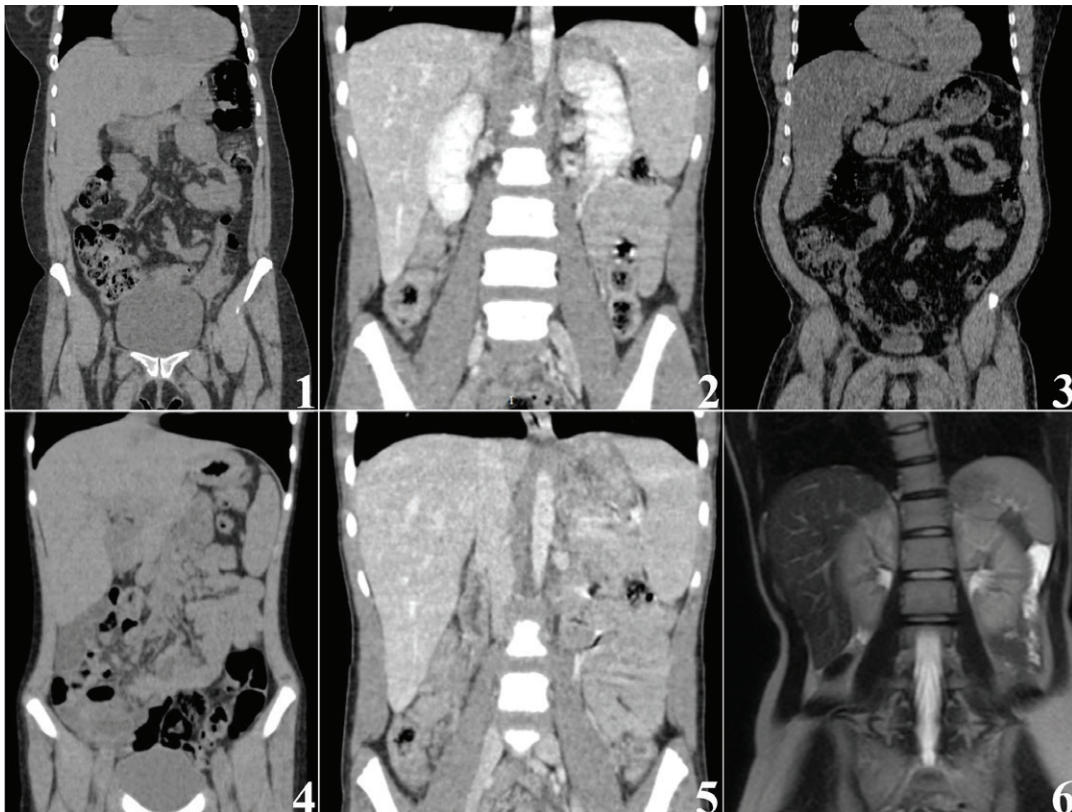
Riedel's lobe incidentally found in different patients through CT (images 1 to 5) and MRI (image 6). Source: Collection of Dr. João Bruno Oliveira Rocha (2023).
